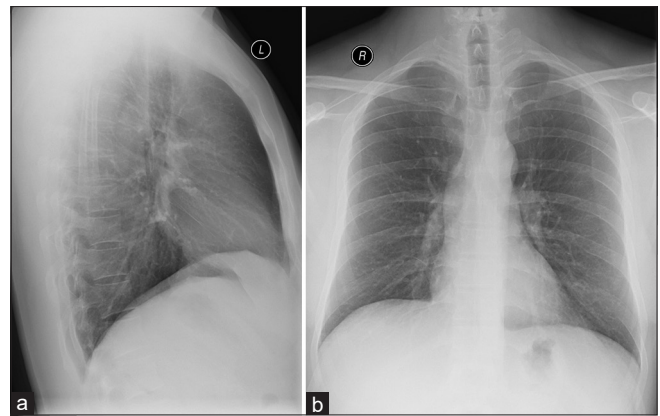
Chest radiography of the patient with no sign of tuberculosis
